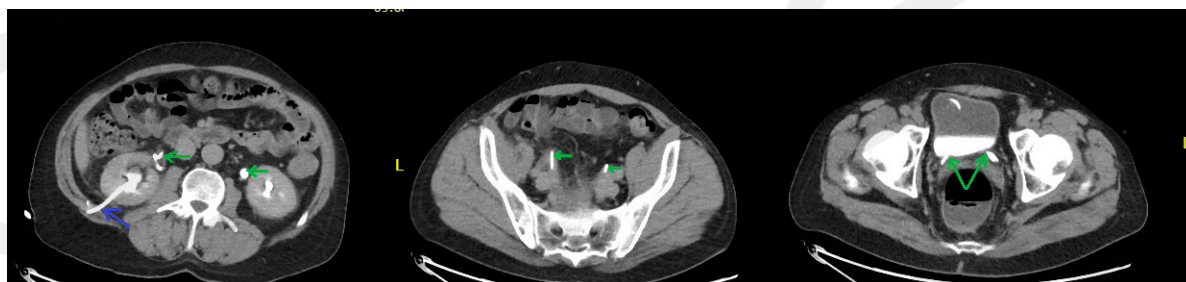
Image of the retroperitoneal space tumour on abdominal and pelvic CT scan – delayed phase. Blue arrow – a nephrostomy, green arrow – DJ catheters
